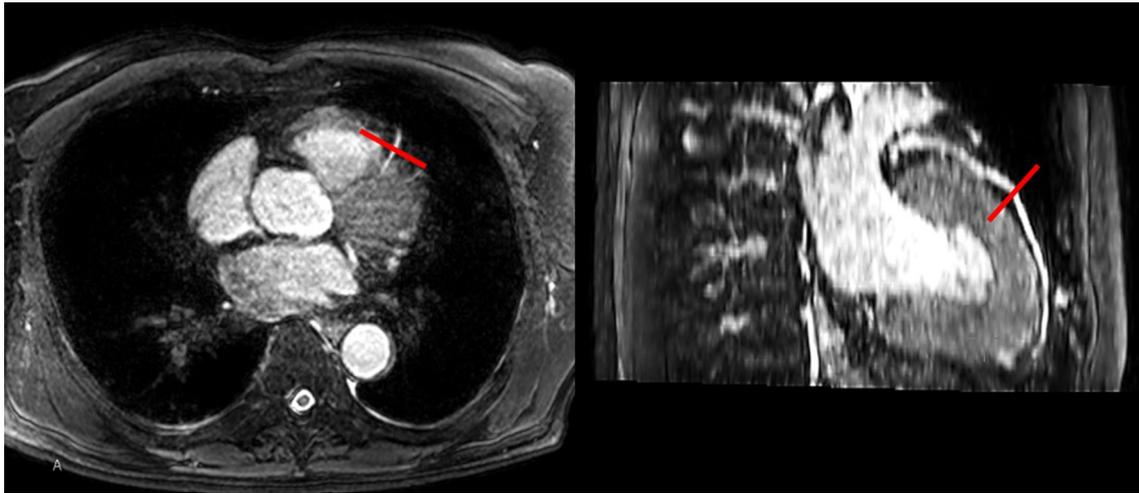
Multiplanar reformation of whole heart coronary MR angiography was used to determine double oblique imaging plane that is perpendicular to the target vessel. PC-MRI was obtained at a site distal to the stenosis
